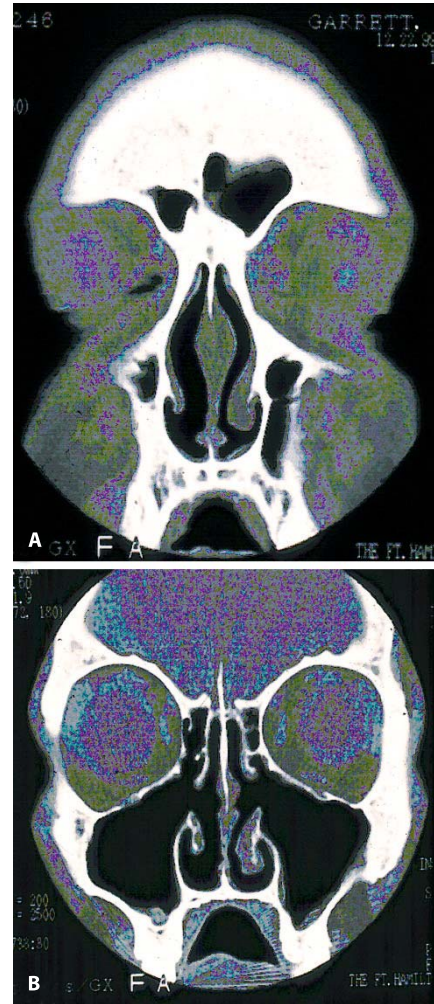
The CT scan of the patient in Fig. 14.6, demonstrating postsurgical changes but no evidence of active sinus disease
